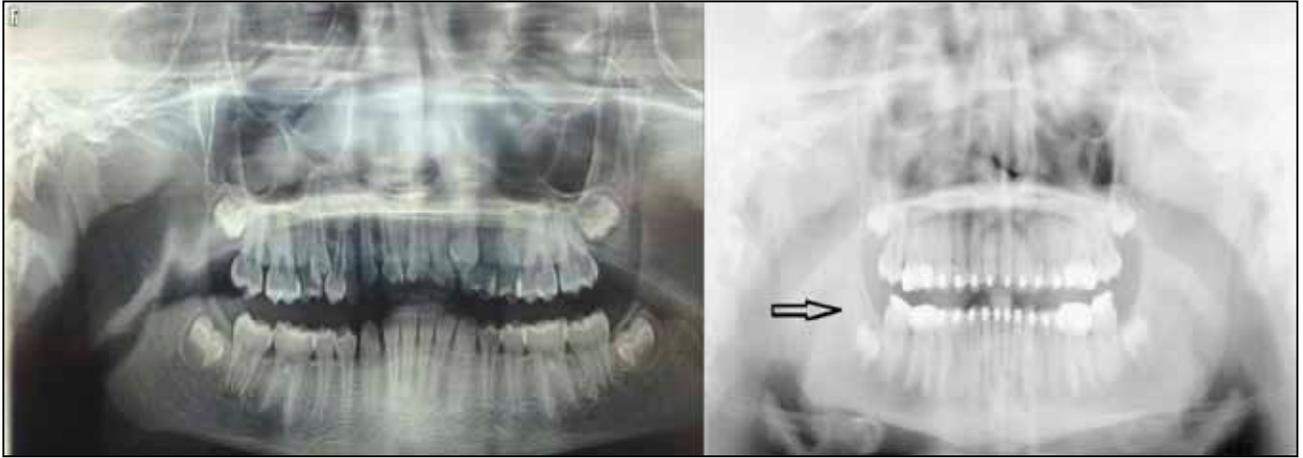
Orthopantomogram - a rounded shadow situated in the right retromolar space, with characteristics of a cystic cavity, filled with rounded mass resembling a tooth germ
